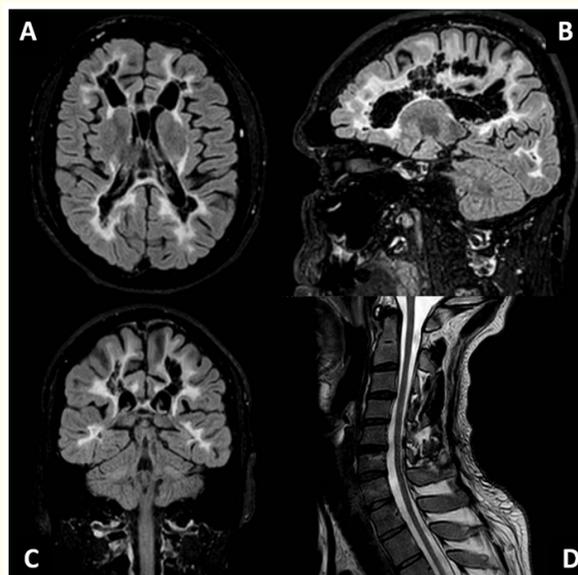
Brain MRI (A, B, C) shows diffuse symmetrical involvement of cerebral white matter with cystic degeneration. White matter presents with T2-FLAIR hyperintensity, extending from periventricular areas to the subcortical arcuate fibers, and over time it is replaced by CSF intensity fluid. Cervical spine MRI (D) shows prominent reduction of spinal diameters due to parenchymal hypotrophy.
